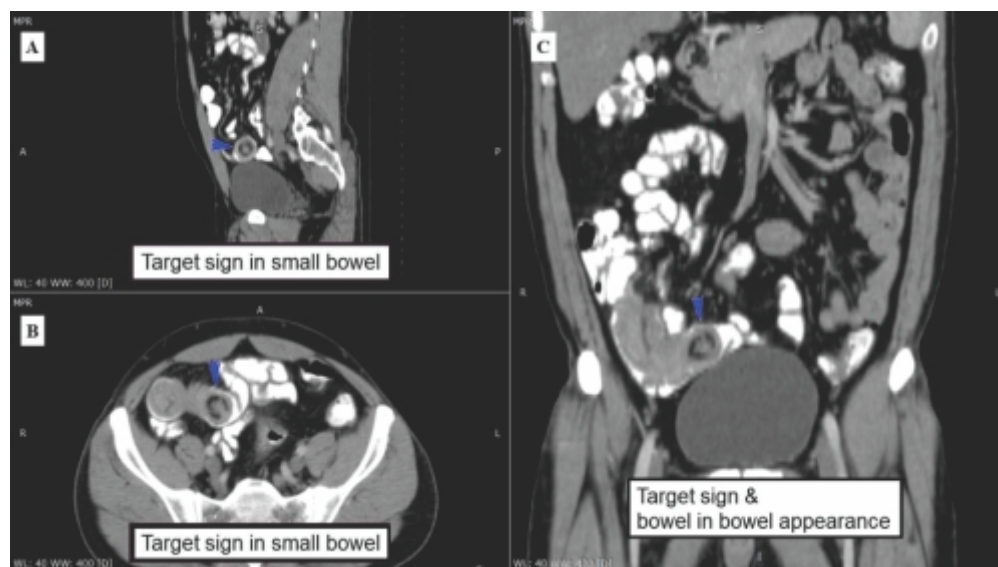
Contrast enhanced computed tomography of abdomen showing the target sign (blue arrow) in sagittal (A) and transverse (B) sections and along with telescoping segments in coronal section (C). The lead-point lesion has low-attenuation fat-density feature.
